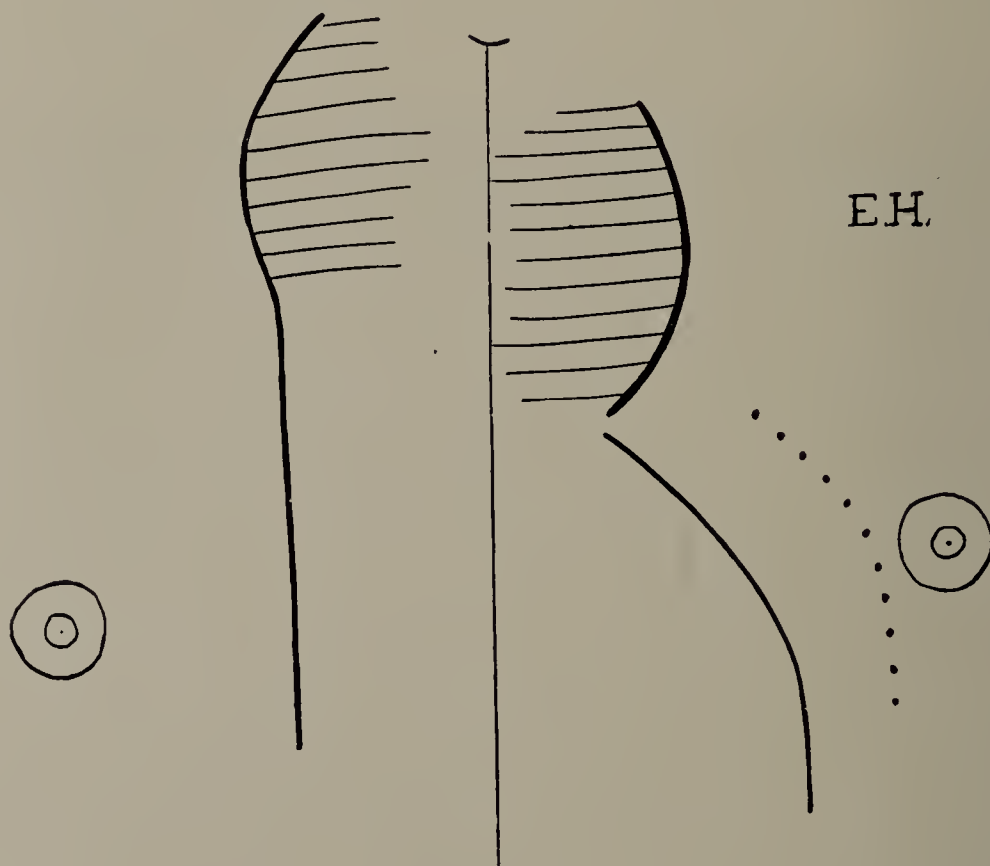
Case II. E. H. Tracing of aneurism of aorta. Aneurism and size of heart seen by X-rays confirmed at autopsy. (Cut ¹ one-third original size.)
